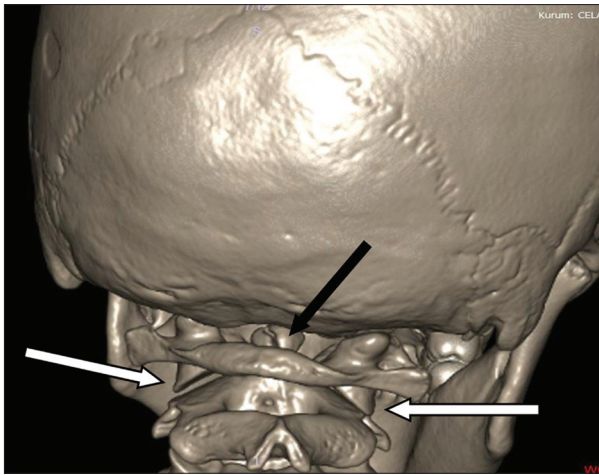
Three dimensional CT scan showing the right lateral translatory subluxation of the atlas over the axis (white arrows) and vertical odontoid fracture (black arrow)
